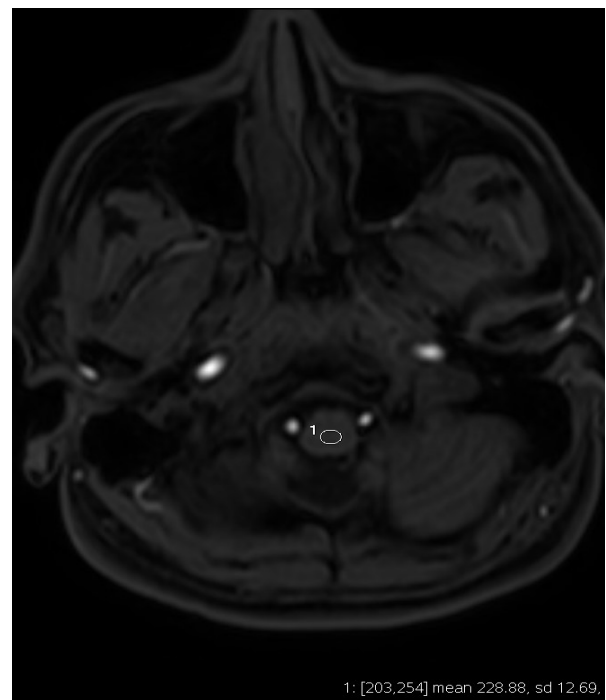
T1-weighted MR images with mDixon techniques for fat suppression. ROIs are placed on the spinal cord to obtain signal intensities for SNR. (A higher resolution / colour version of this figure is available in the electronic copy of the article).
